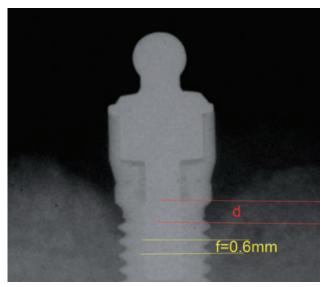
Using an image analysis software, the radiographic bone level change is measured. The software is calibrated using the known distance between the implant threads (f = 0.6 mm) as the reference to determine the bone-loss level ("d").
